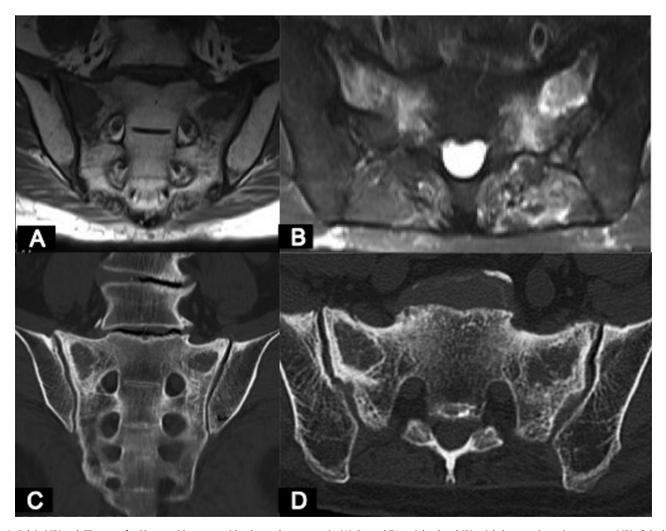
Pelvic MRI and CT scans of a 68-year-old woman with advanced osteoporosis. (A) Coronal T1-weighted and (B) axial short tau inversion recovery MRI of the bone surrounding the bilateral sacral alar insufficiency fracture. (C) Coronal and (D) axial sacral bone CT scans showing the bilateral sacral alar area of sclerotic hyperdense signal representing the sacral alar insufficiency fracture.
